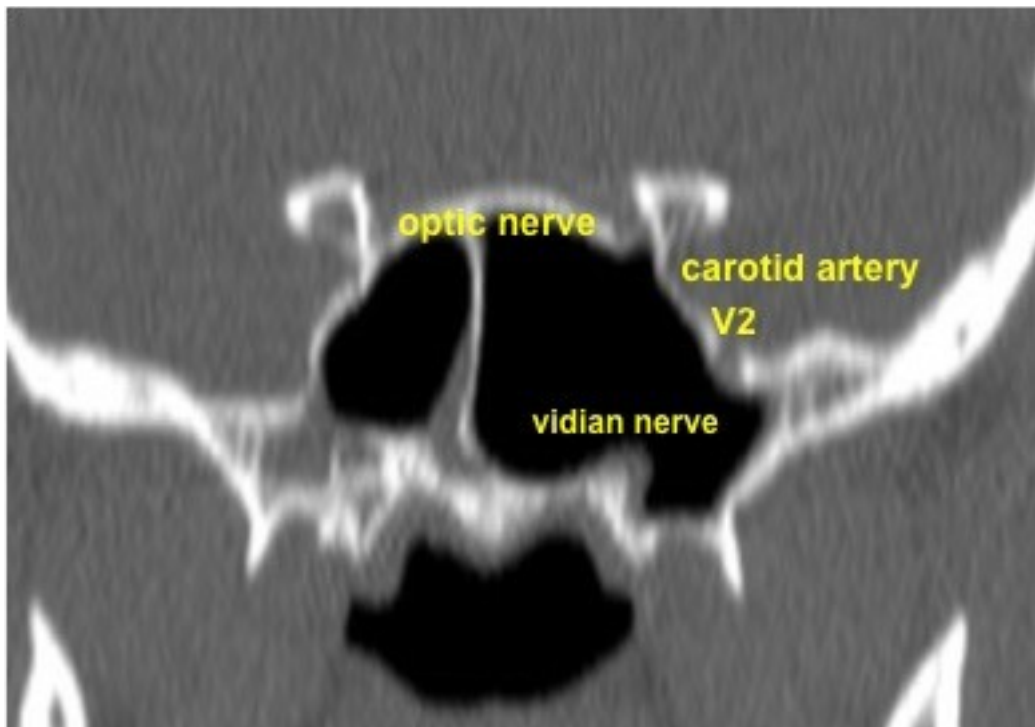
Detailed sphenoid sinus anatomy on a CT with important neurovascular structures.
